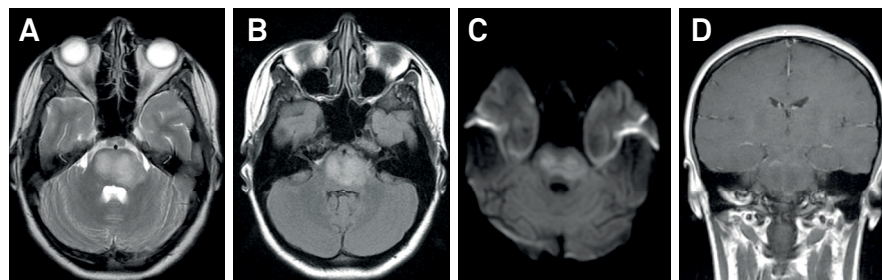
Brain MRI. (A) Axial T2 weighted and fluid-attenuated inversion recovery (FLAIR) (B) images demonstrating a hyperintense brainstem lesion with increased signal in diffusion-weighted image (DWI) (C). Coronal T1 weighted post-gadolinium image (D) show mild peripheral enhancement.
